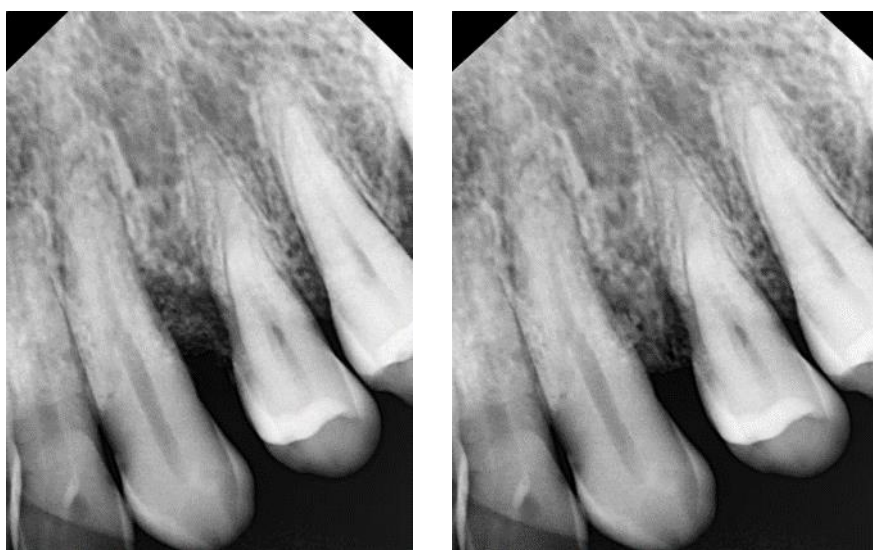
Experimental site B – Pre-operative radiograph
